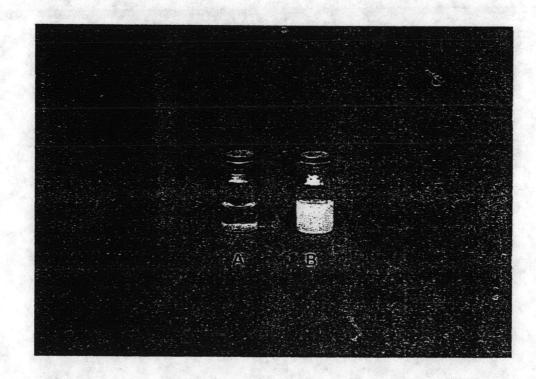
Chitin (A) and ethylcellulose (B) aqueous dispersions after 3 hours standing of the CT dispersion positively resulted in easily redispersible property of the product only by gently shaking.
